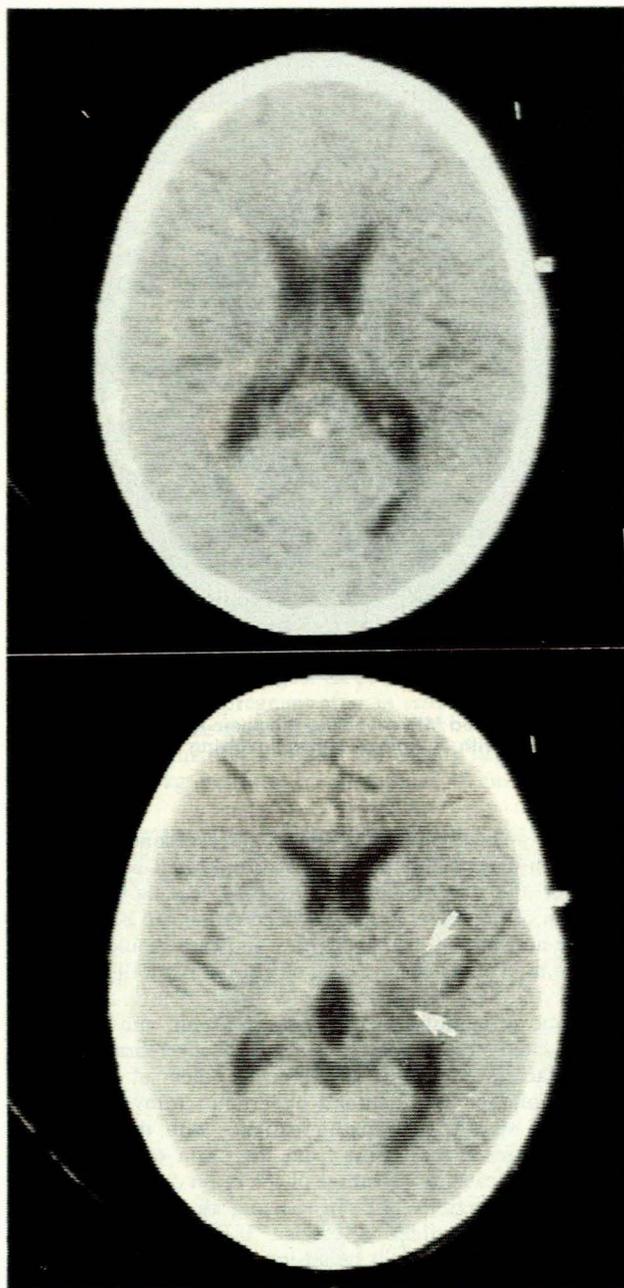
Follow-up CT at 3 weeks demonstrating return to normal of the lateral ventricles, sulci and white matter (above). CT demonstrating low densities in the right thalamus (arrows) (below).
